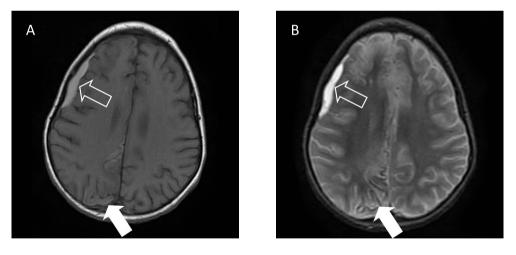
Case 8. Axial T1-weighted MR image of a 3-year-old boy who fell from the stairs. Information not available to the participating radiologists: The boy was brought to the hospital comatose, according to parents he had fallen from the stairs that night. Signs of physical abuse were found all over his body. He was admitted for several weeks, this MR scan was made 2.5 weeks after the incident. Police investigations revealed that the day before admission he had been seen in good condition by several people. In the night before admission the neighbors had heard him crying for several hours. MR image shows a hyper intense right sided SDH (open arrow). Subcortical laminar necrosis is visible (arrow). Figure 8b. Axial T2-weighted MR image of the same boy shows a hyper intense SDH (open arrow) and hemosiderin depositions in the subcortical laminar necrosis (arrow).
